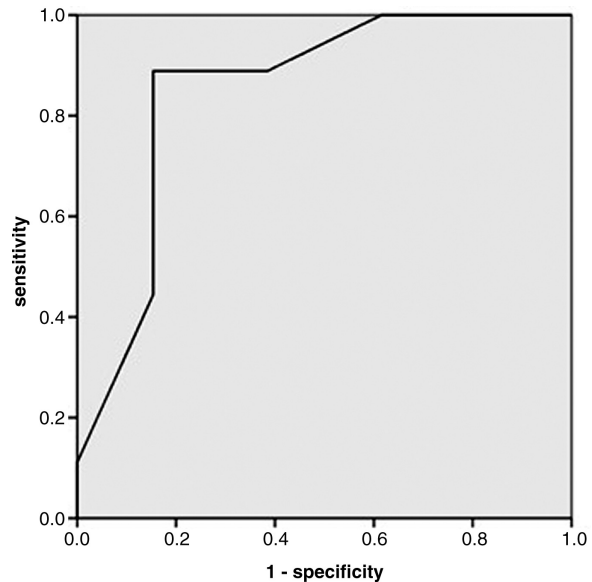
Receiver operating characteristic curve for 90-day good outcome by posterior circulation acute stroke prognosis early CT score.
